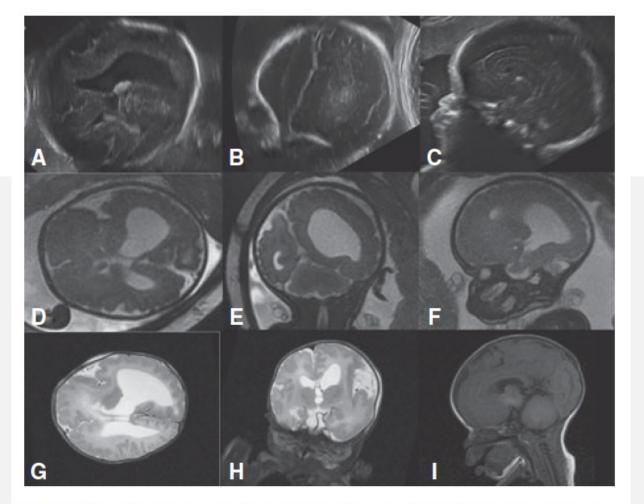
Hemimegalencephaly diagnosed by US at 28 postmenstrual weeks of gestation (A–C) with MRI confirmation at 29 weeks of gestation (D–F) and following delivery (G–I). The clinical course was complicated by refractory epilepsy. Note the difference in the size of the cerebral hemispheres and lateral ventricles. The corpus callosum is thick (C, I), and the vermis not observed in the midline (E, I). Abnormal sulcation in the left hemisphere is suggested on fetal images and clearly depicted in both hemispheres on postnatal MRI (G, H). (Courtesy of Dr. Mauricio Herrera, Bogotá, Colombia.)
